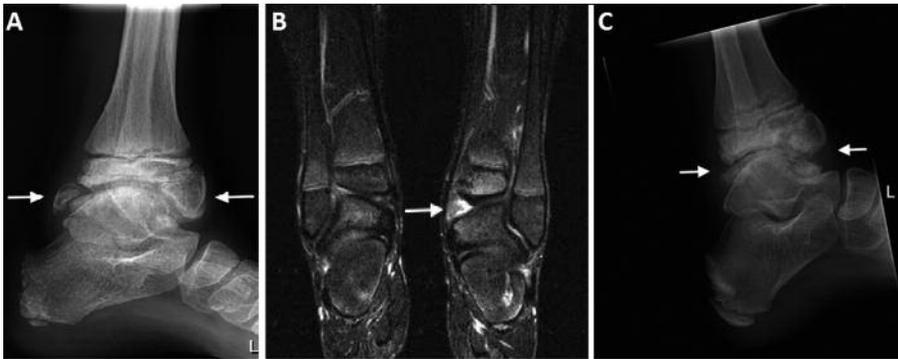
A Pre-operative lateral conventional radiograph of the left ankle; B Pre-operative coronal STIR MRI scan (TR 2000/TE 55) of both ankles; C Post-operative lateral conventional radiograph of the left ankle.
